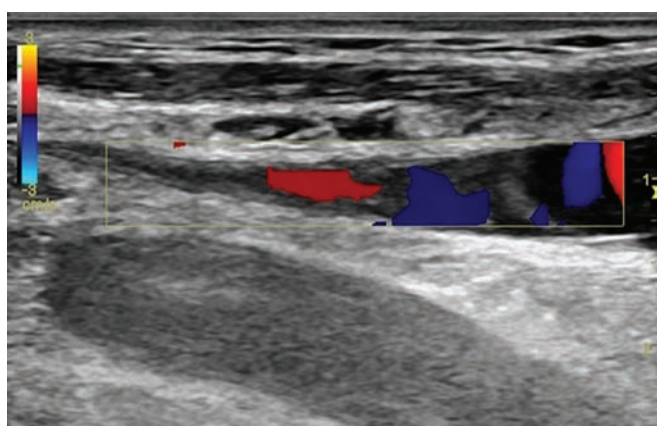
Color Doppler of the left carotid artery showing adequate blood flow through the graft
